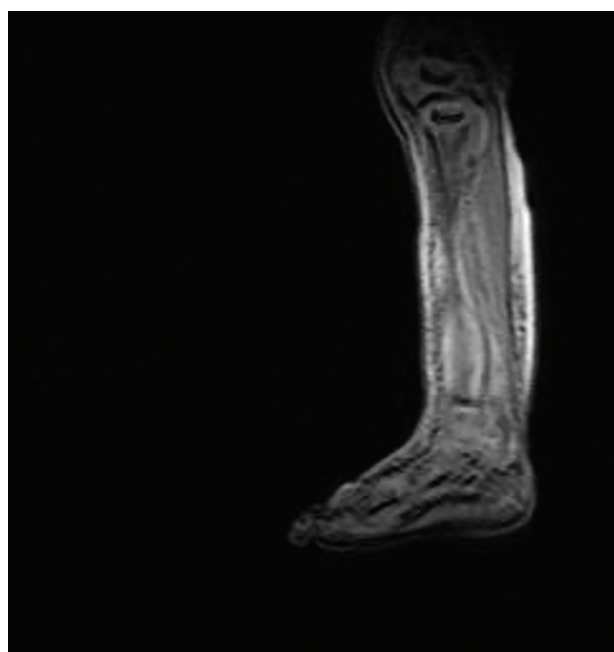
Sagittal MRI view suggestive of aggressive infection.
